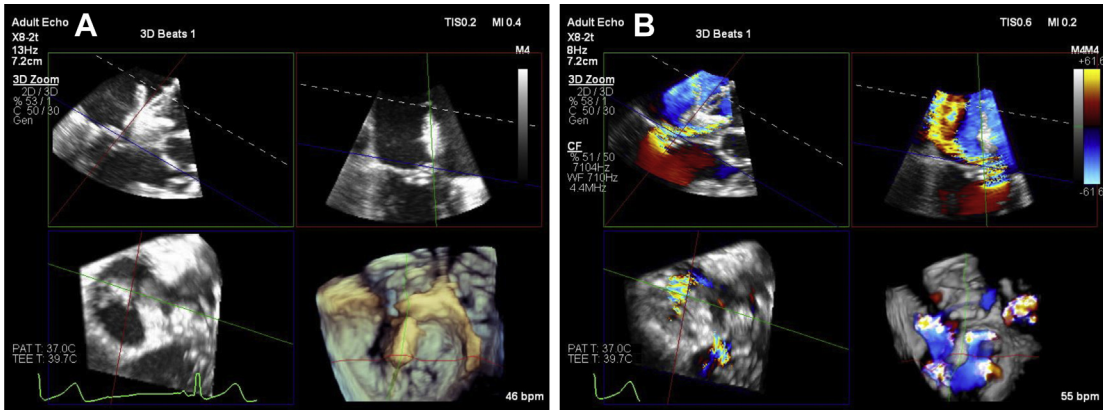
Positioning and alignment of the clip in the LA using MPR. (A) Live MPR is used to simultaneously visualize all key views for alignment of the CDS in the LA: long axis view (*upper left*), bicommissural view (*upper right*), short axis view (*lower left*) and 3D *en face* lower right. The green plane is aligned with the clip arms in the short axis and 3D views to display the arms in the open position. (B) Once standard views are obtained and clip is aligned to target, color Doppler is added to confirm that the clip is aimed at the MR jet. LA, left atrium.
